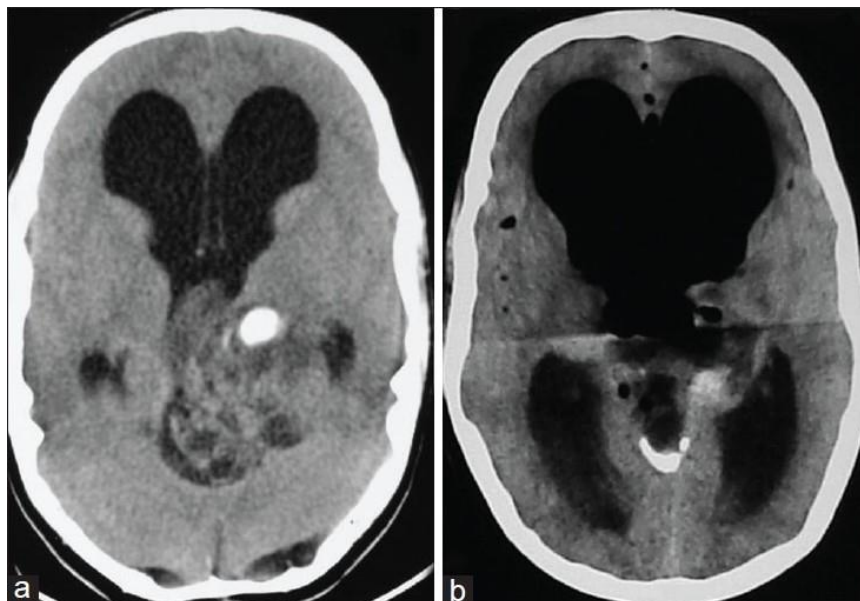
CT scan shows the neoplasm of brain.
